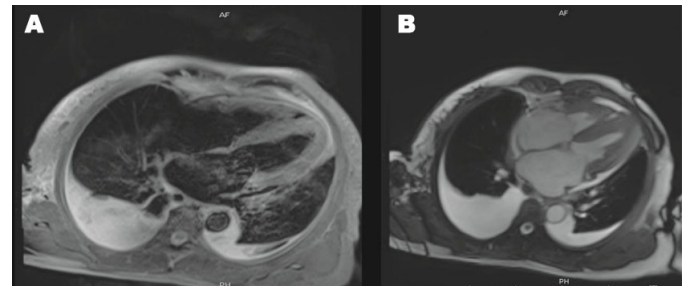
Diffuse tissue enhancement of the heart, involving the left ventricle, right ventricle, and left atrium, by gadolinium was shown on MRI.
